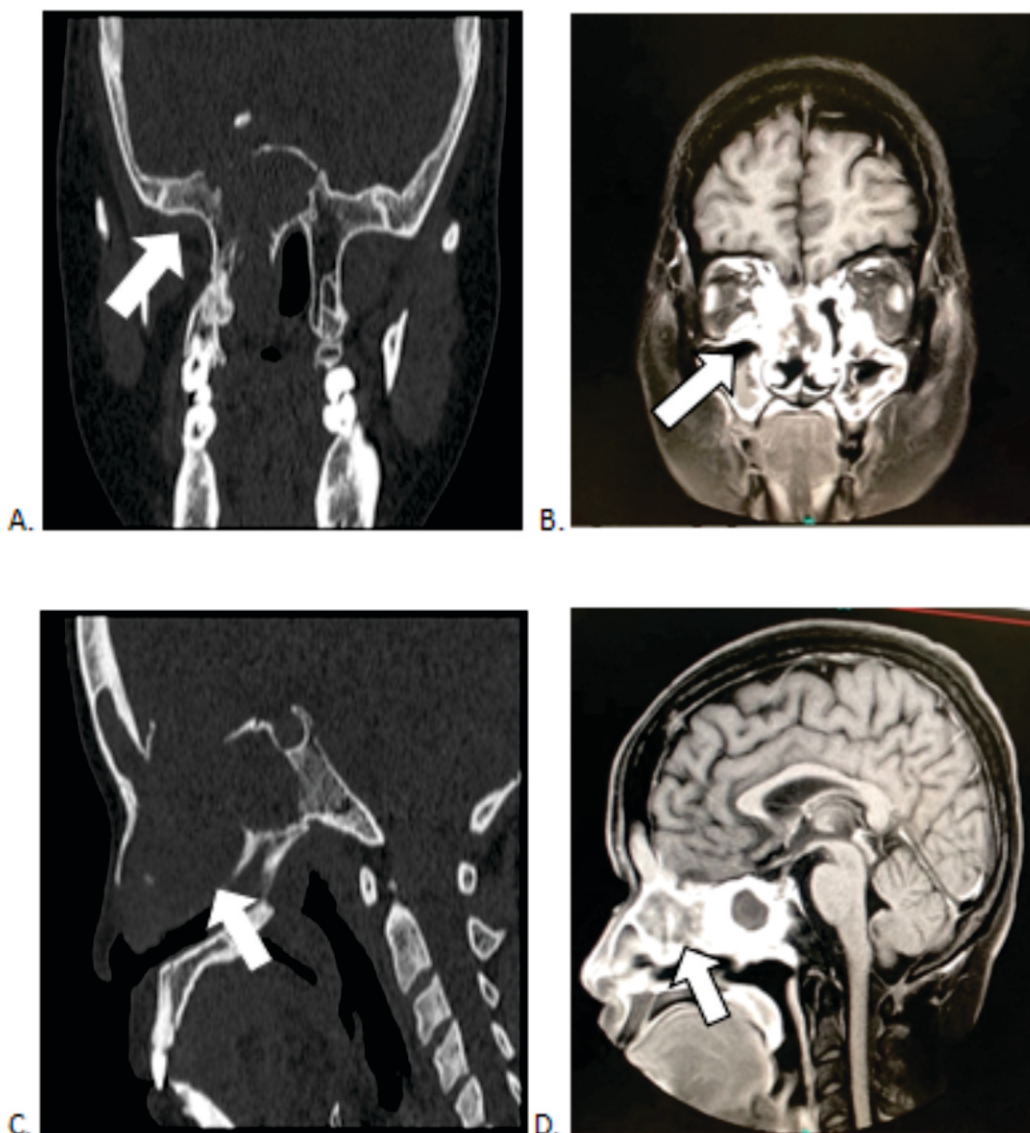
A comparison of the previously seen mass using cranial magnetic resonance imaging with intravenous contrast. A and C shows the previously seen large enhancing mass occupying the nasal cavity and paranasal sinuses. B. An interval decrease in the size of the previously seen lobulated, heterogeneously enhancing, expansile mass occupying the nasal cavity, more on the right, approximately measuring 57.3 x 34.1 x 39.9 mm (AP x T x CC; previous remeasured at 61 x 36 x 48 mm). There is bony destruction of the paranasal sinus walls. D. The mass extends superiorly and completely opacifies both frontal sinuses. Laterally, the mass extends to both orbits causing displacement of both medial rectus muscles, more on the right, abutting the thickened right optic nerve. There is interval resolution of the right ocular proptosis.
